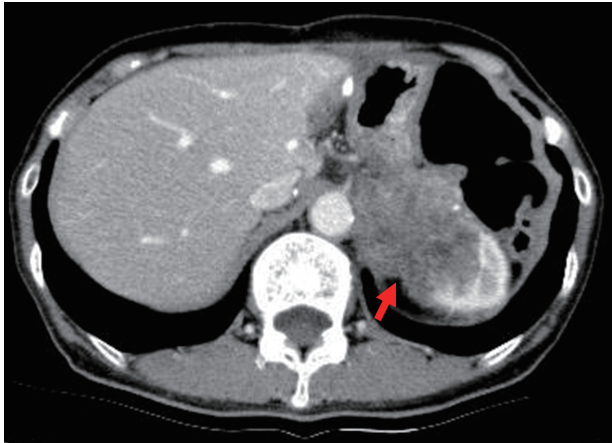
Computed tomography 12 months after liver metastatic tumor resection
